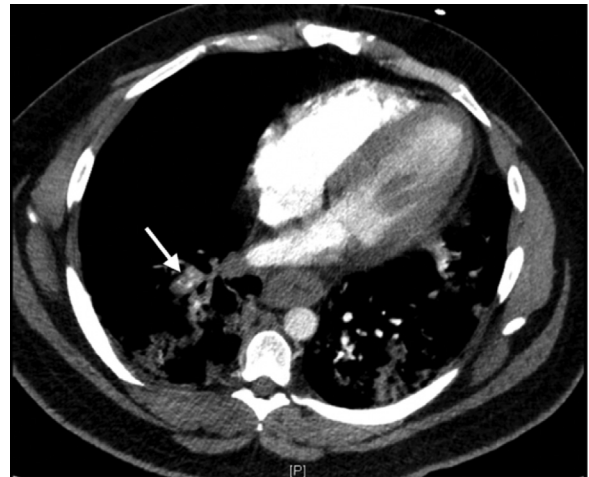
Axial contrast enhanced CT images of the chest: nonocclusive filling defect within the lateral basilar segmental pulmonary artery (white arrow), which is consistent with pulmonary arterial thromboembolic disease.
